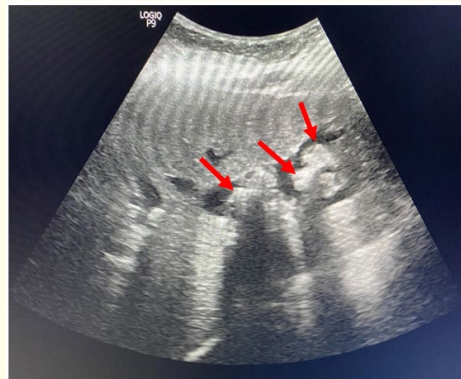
Hepatic ultrasound image in B mode showing a dilated bile ducts with the presence of hyperechoic formations generating a posterior acoustic shadowing indicative of bile ducts lithiasis (Red arrows).
